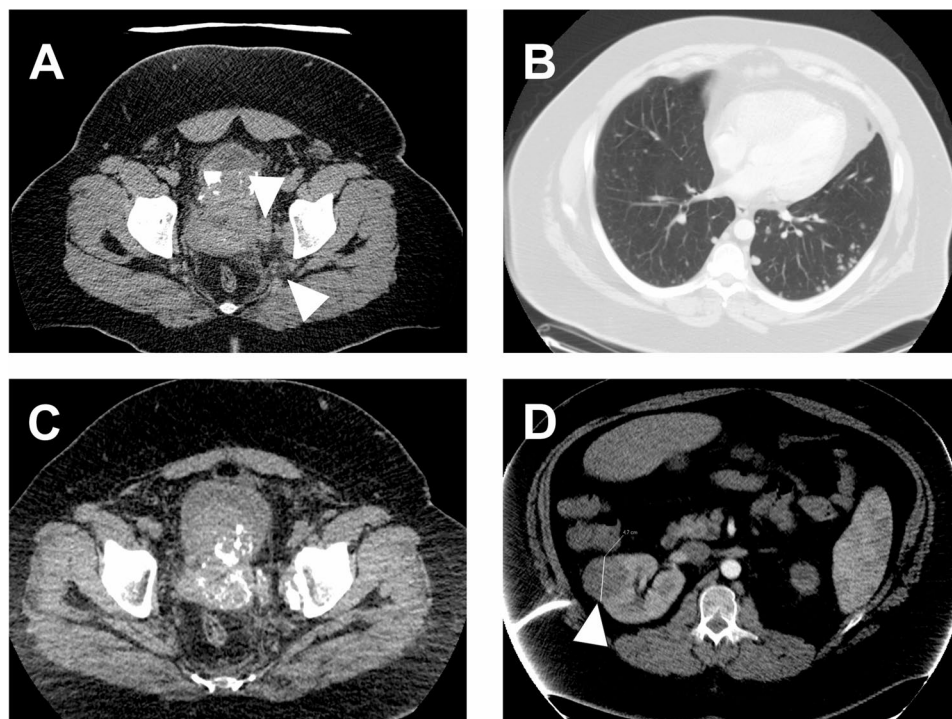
CT scans of the abdomen and body. A large tumor mass behind the bladder at the time of diagnosis (A, arrow heads). Multiple pulmonary metastases 1 month after diagnosis (B). Progression of the calcified tumor 26 months after diagnosis (C). Metastatic tumor mass of the right kidney marked by arrow head, approx. 4.7 cm in diameter, 23 months after diagnosis (D)
